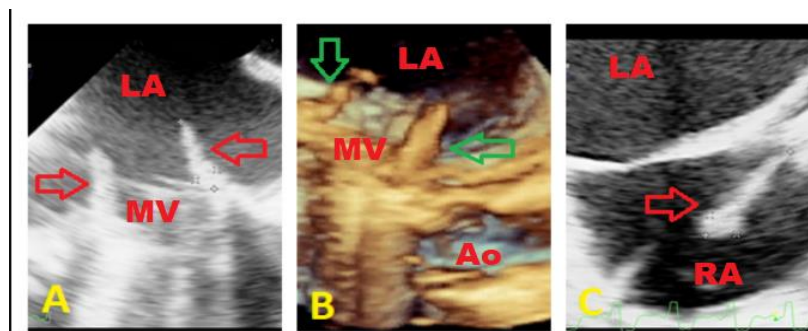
Transesophageal echocardiography demonstrating, A; Vegetations on prosthetic mitral valve (Red arrow), B; 3D-TOE of vegetations on mitral valve (Green arrow), C; Vegetation on pacemaker lead in right atrium (Red arrow). Ao; Aort, LA: left atrium, MV; Mitral valve, RA; right atrium.
